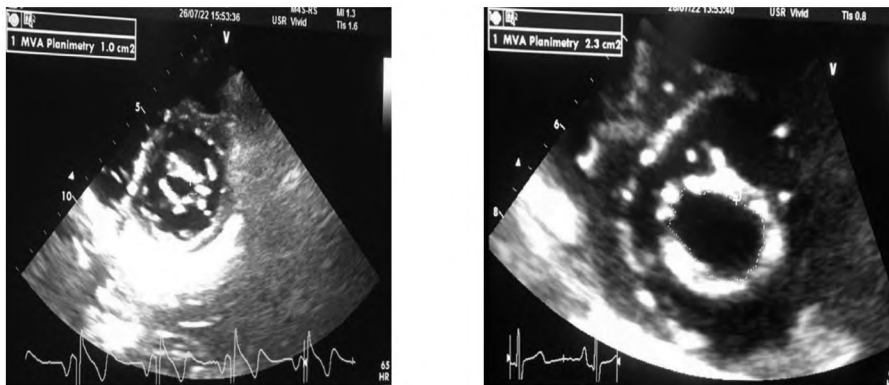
Parasternal short axis view of the mitral valve at the level of the tips to measure mitral valve area (MVA) by planimetry before (right) and after (left) PMC.
